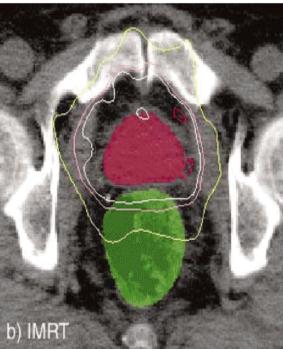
Isodose comparison between (a) CyberKnife and (b) IMRT plans in the same prostate mid-axial plane (small differences in the appearance between CT slices are artifacts due to differences between each system's graphic software). The isodoses shown are, from lowest to highest: 50Gy, 70Gy, 74Gy and 81Gy. Prostate and rectum are shown by the dot-solid lines for CyberKnife and color wash for the IMRT. Note that the 74Gy isodose (100% prescription) encompasses the prostate.
